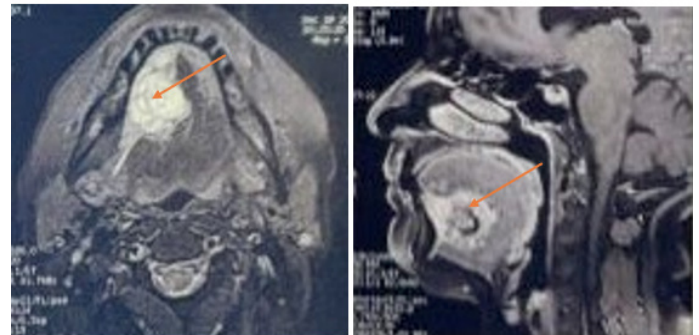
Magnetic resonance imaging of the floor of the mouth (A) Axial T2-weighted image showing a well-defined hyperintense lesion arising from the right sublingual gland (arrow). (B) Sagittal contrast-enhanced T1-weighted image demonstrating a well-circumscribed enhancing mass without obvious invasion of adjacent structures (arrow).
